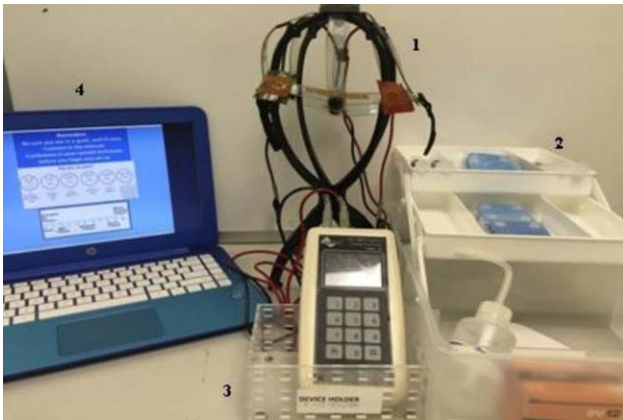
Participant study materials. 1) Headstrap with cap-like design; 2) Device kit with materials labeled for daily use; 3) Mini-CT device with large, easy-to-use response pad; 4) Study laptop configured with VSee, TeamViewer, and daily assessment scales.
